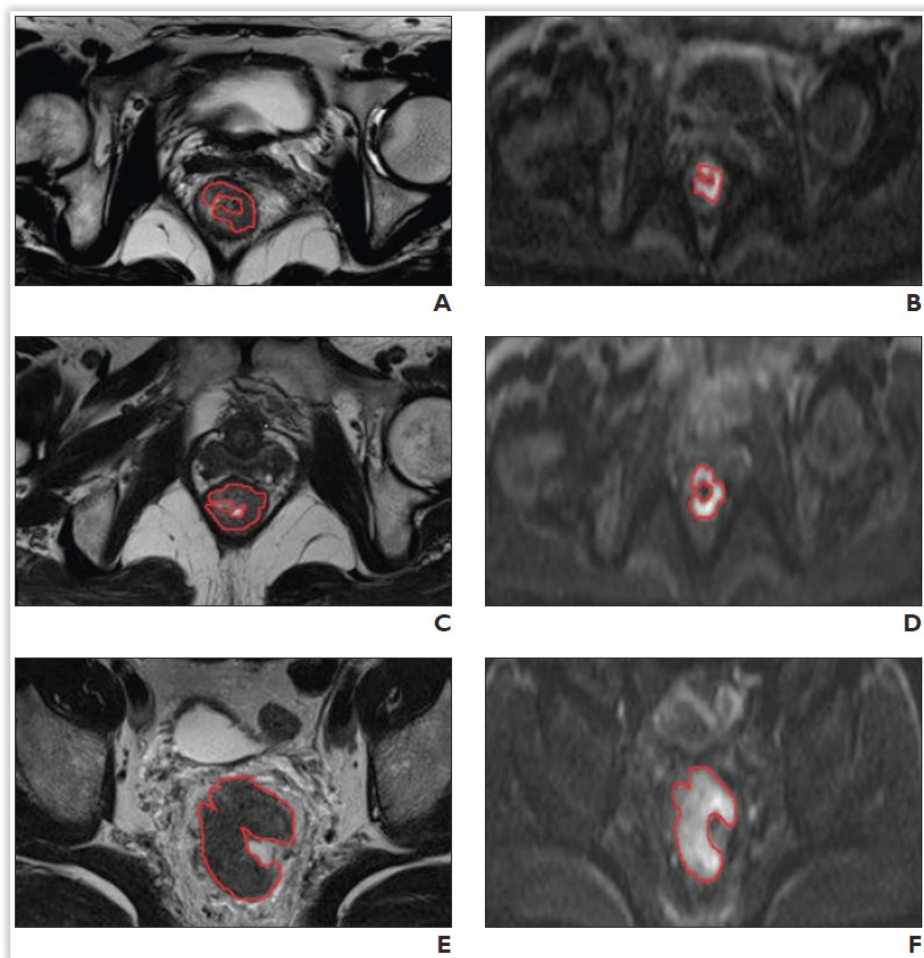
Calculation of gross tumor volume (GTV) of well-defined rectal tumors. After manual tracing of lesion outer edge on each image (red line), GTV was automatically calculated as sum of cross-sectional volumes. A and B, Oblique axial T2-weighted MR (A) and DW (B) images show well-defined rectal tumor in 51-year-old woman with pathologically proven T1N0 disease but no lymphovascular invasion (LVI). GTV was 8.35 cm³ in A and 7.98 cm³ in B. C and D, Oblique axial T2-weighted MR (C) and DW (D) images show well-defined rectal tumor in 60-year-old woman with pathologically proven T2N1 disease but no LVI. GTV was 15.59 cm³ in C and 14.97 cm³ in D. E and F, Oblique axial T2-weighted (E) and DW (F) image show well-defined rectal tumor in 63-year-old man with pathologically proven T4aN2 disease and LVI. GTV was 42.45 cm³ in E and 39.40 cm³ in F.
